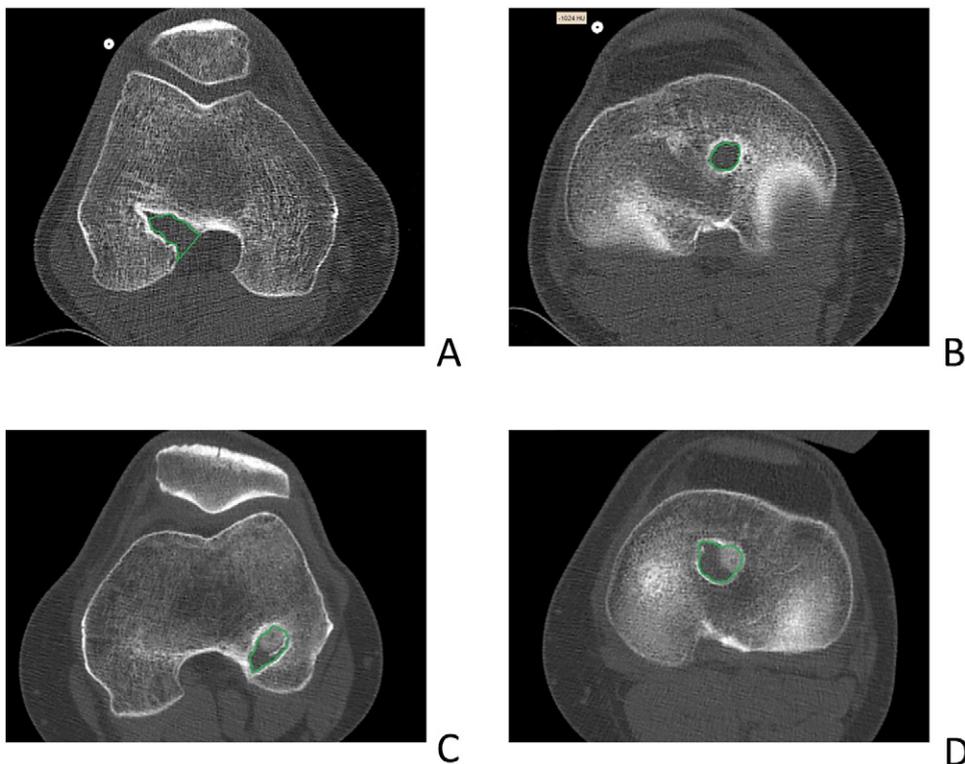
Measurement method of bone tunnel volumes on CT scans shown on exemplary images at six months of follow-up. The cross sectional area of the femoral and tibial bone tunnel with button (A, B) or screw fixation (C, D) was marked on axial CT slices.
